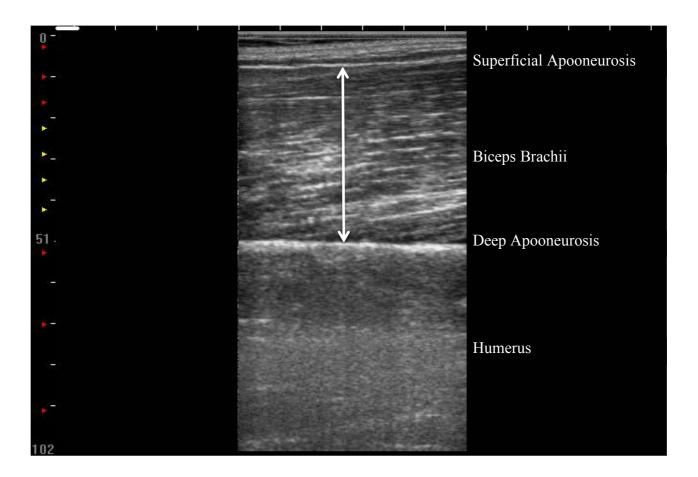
Example of an ultrasound scan used to assess muscle thickness.
